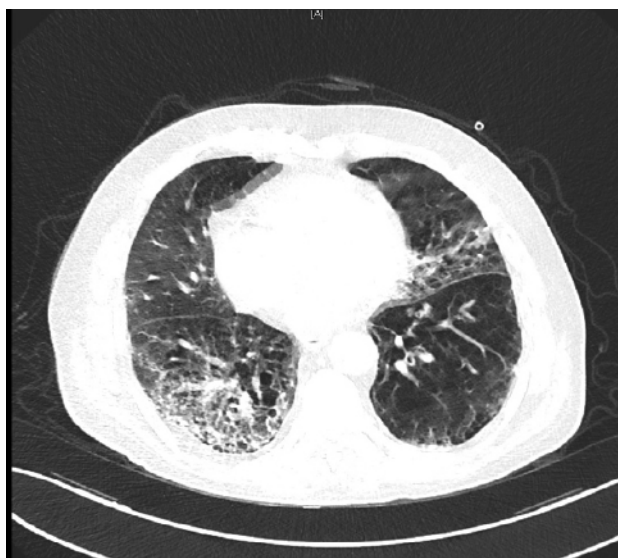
Chest CT scan with COVID-19.
